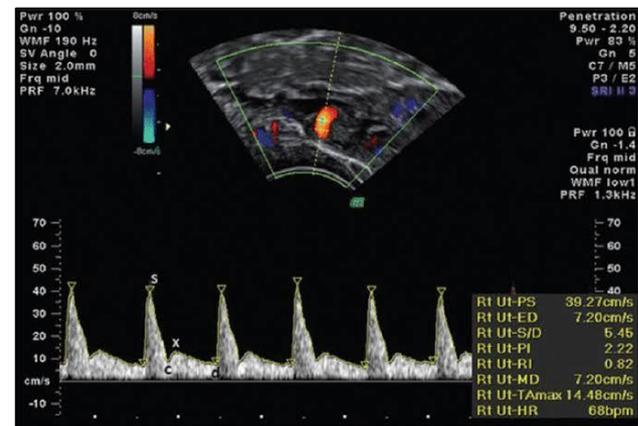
Uterine artery doppler with diastolic notch.
